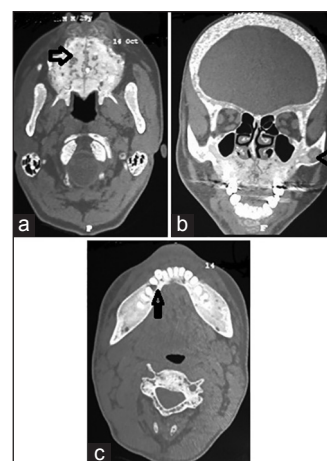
CT scan; (a) axial view shows multiple small unilocular well-defined radioluscencies, suggestive of brown tumors in hard palate (arrow); (b) coronal view shows a well-defined radioluscency in zygoma (arrow); (c) axial view shows multiple small unilocular well-defined radioluscencies in the mandibular body (arrow)
